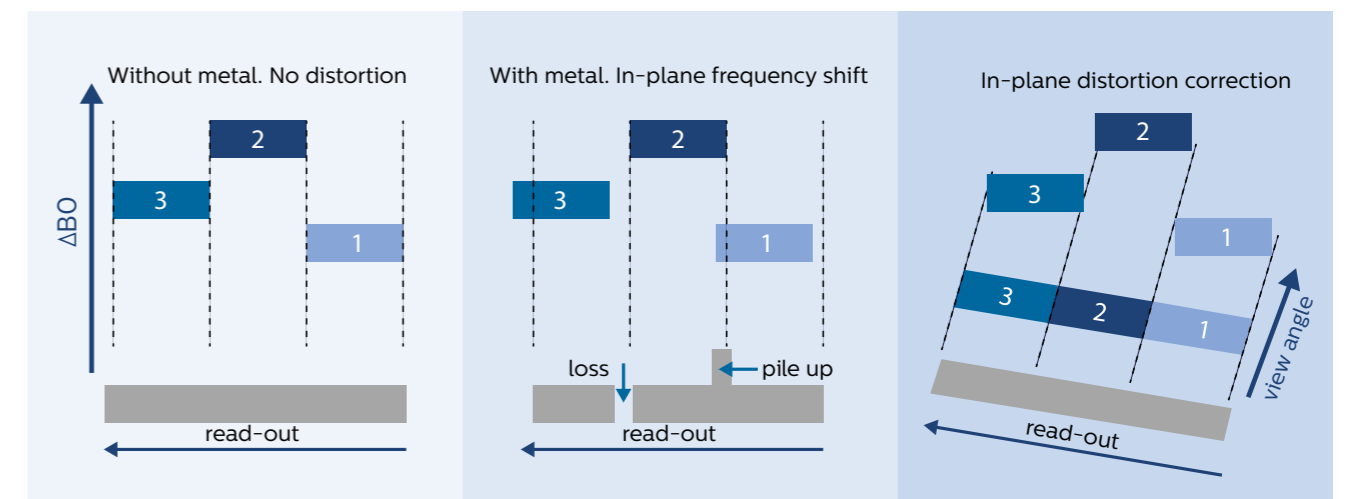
View Angle Tilting principle. In the presence of metal implants frequency shifts occur, resulting in in-plane signal loss or pile up. By tilting the readout direction using a gradient on the slice select axis during readout that is of the same amplitude as the slice select gradient, the received signals can be projected into the correct pixel of the image matrix. Although in-plane spatial distortion is considerably reduced, blurring can be introduced into the MR image.
